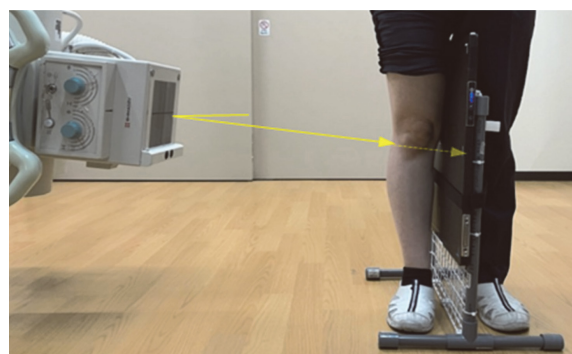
Lateral X-ray of knee joint in standing position with both legs
